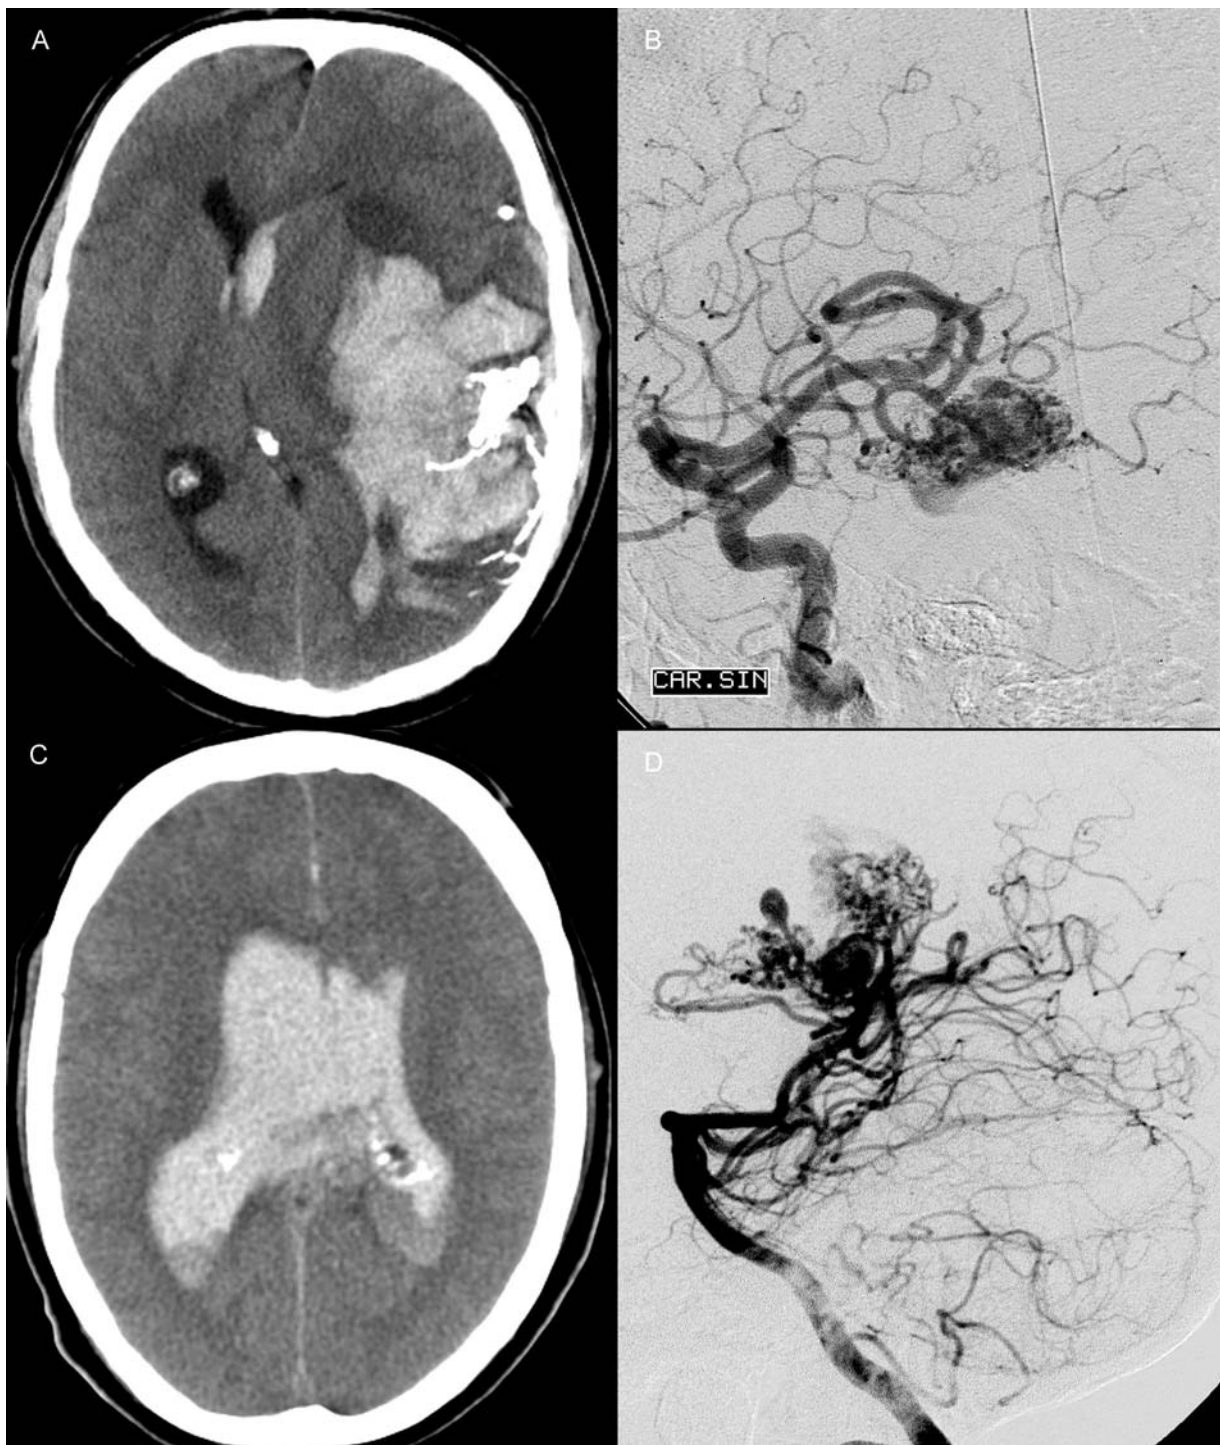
(A) A huge intraparenchymal haematoma (*ICH*) two days after embolization of (B) a left temporal arteriovenous malformation (*AVM*) in 39-year-old male. Preoperatively Hunt and Hess Grade (*HH*) was 5. *ICH* was evacuated and *AVM* extirpated, resulting in vegetative state at 3 months after bleed, and finally severe disability. (C–D) 38-year-old male admitted deeply unconscious (*HH* 5) to hospital. (C) CT scan showing massive intraventricular haematoma. (D) Vertebral angiography revealed a trigonal *AVM*, which was extirpated. Unfortunately the patient did not survive
